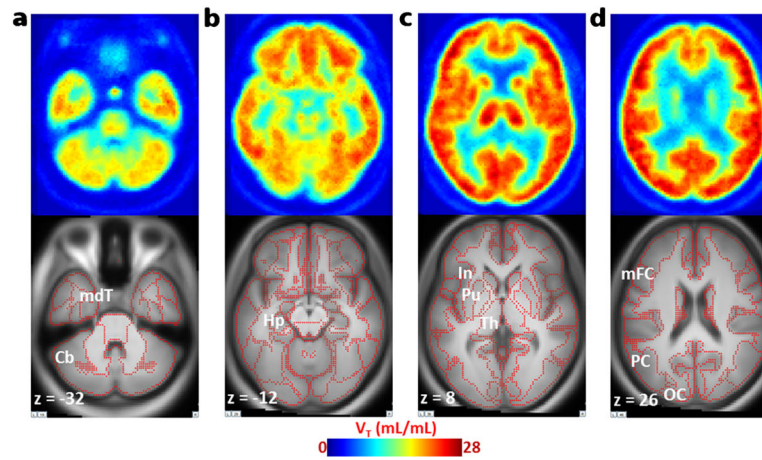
Averaged ($n=5$) transaxial images of spatially normalized V_T map of [^{18}F]ASEM and matching MRI in healthy control subjects. a Cerebellum (*Cb*) and medial temporal cortex (*mdT*) showed relatively low V_T values; b hippocampus (*Hp*) showed medium V_T values. c The insula (*In*), putamen (*Pu*), and thalamus (*Th*); d middle frontal (*mFC*), parietal (*PC*), and occipital (*OC*) cortices exhibited high V_T values in the human brain. *Red dots* on MRI images indicate outlines of cortical and subcortical structures.
